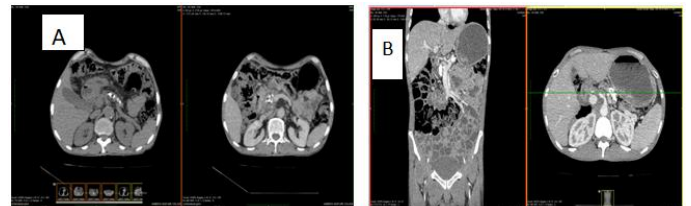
CT unenhanced and enhanced axial (A) shows diffuse atrophy of pancreas with multiple calcific foci in parenchyma and Coronal (B) parenchymal phase shows coarse calcification within pancreatic head and body region.
